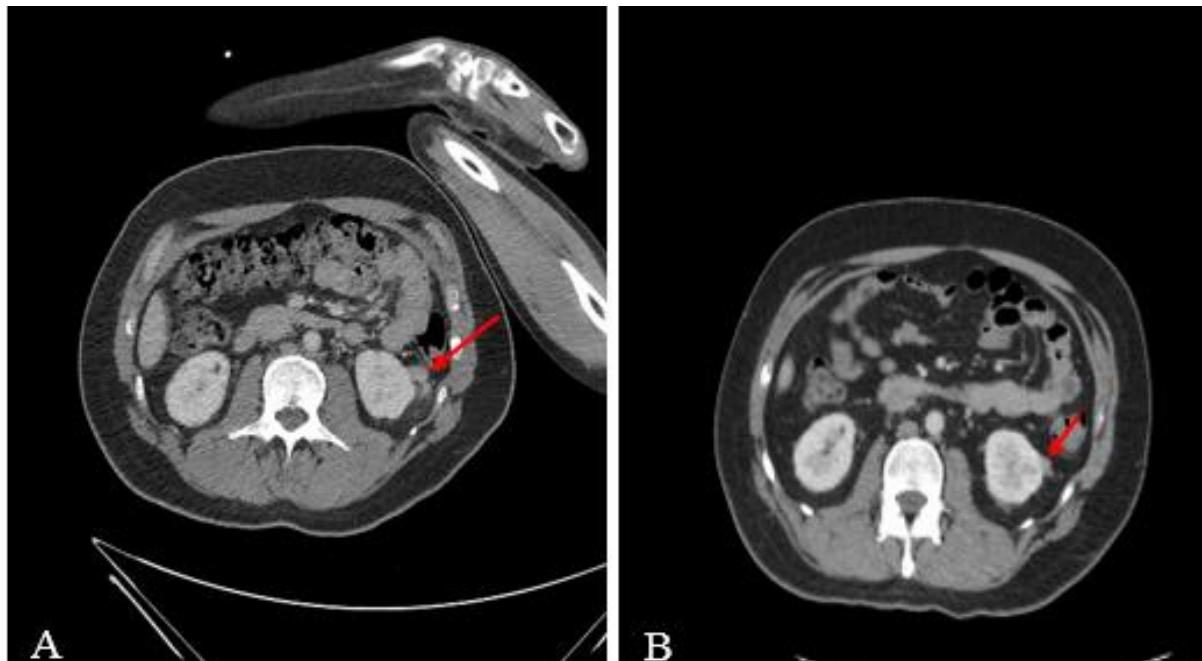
Renal CT performed in 2014 (pre-treatment) shows an angiomyolipoma measuring 2.2 cm arising from the lower pole of the left kidney (A). Follow up renal CT (36 months post treatment) shows a decrease in size of the same lesion to 1.2 cm (B).
